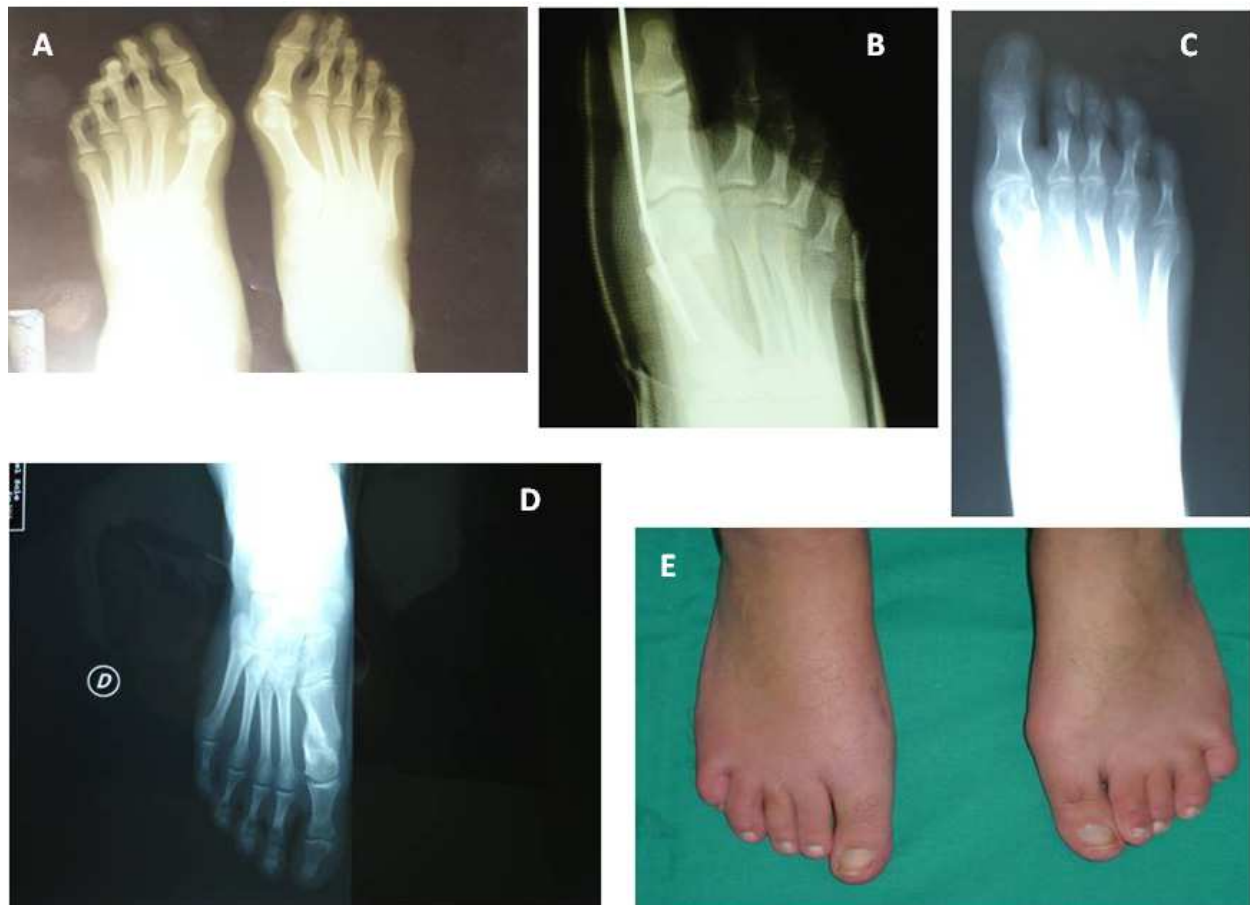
14 years old female with bilateral hallux valgus deformity. The patient had been already treated for flatfoot. A, preoperative X-ray; B, Postoperative X-ray; C, X-ray control 4 weeks later; D-E, X-ray and Clinical Control after 1 year.
